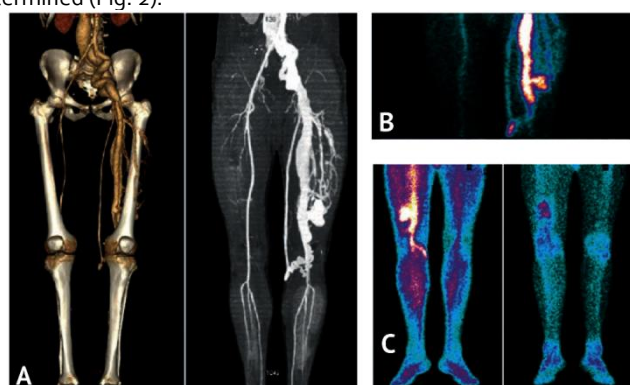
Hybrid examination: A — CT-angiography of lower extremities: VRT and MIP (anterior projection). Dilated vasculature within the soft tissues of the left thigh, left iliac and femoral arteries and veins, as well as vena cava inferior and cavity of pseudoaneurysm filled with the contrast agent; B — radionuclide angiography (anterior projection): dilated femoral artery and pseudoaneurysm of distal femoral third; C — scintigraphy in soft tissue-phase and bone-phase (posterior projection): microcirculation disorder seen as increased radiotracer uptake in the region of knee joint and focal radiotracer accumulation in the cavity of the pseudoaneurysm
